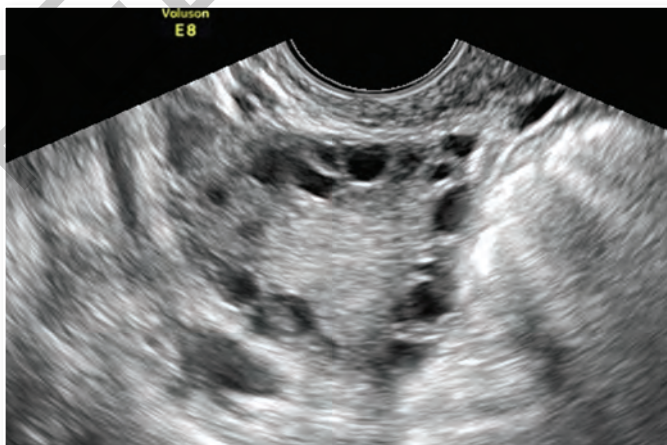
Transvaginal ultrasound demonstrates bilaterally enlarged ovaries (right ovary 12 cm³ and left ovary 15 cm³), multiple small peripheral cysts measuring between 2 and 10 mm (15 cysts on the right, and 18 cysts on the left ovary), around a dense core of stroma
